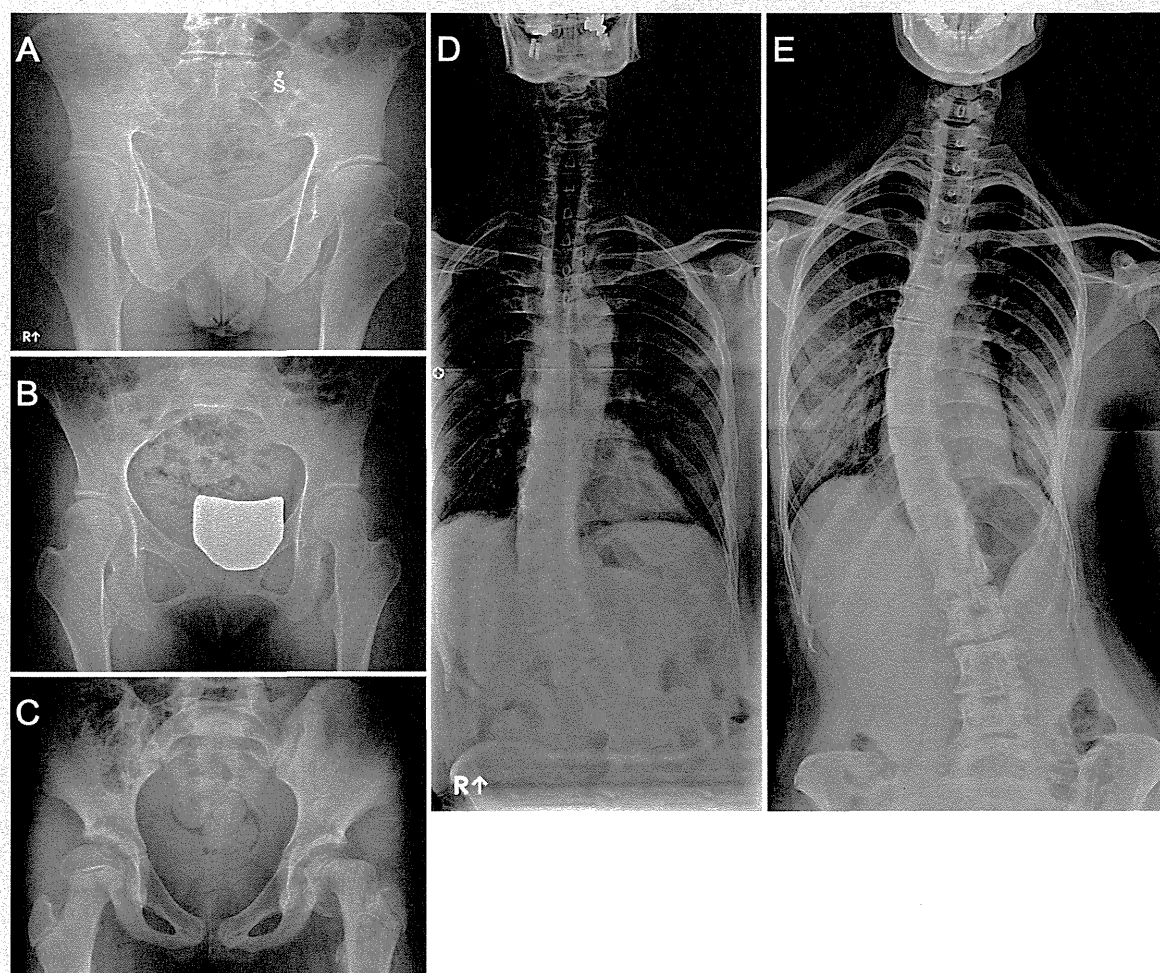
Radiographs of the pelvis and spine of the other affected family members. Marked coxa valga deformity and residual valgus slipped capital femoral epiphysis are seen in Patients III-3 (A) and IV-1 (B). C: Coxa valga deformity and unstable aggravation of the slipped capital femoral epiphysis at the left hip are seen in Patient IV-3 at age 11 years. D: Patient III-3 and (E) Patient IV-1 show thoracolumbar scoliosis. The vertebral bodies are tall and narrowing of the disc spaces is noted.
